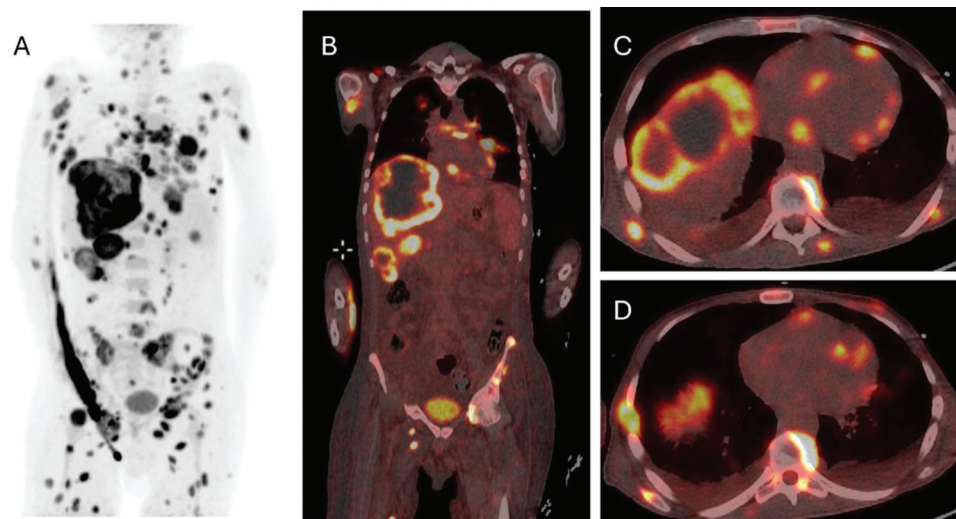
Patient 1 Whole-body PET maximum intensity projection (MIP) image (A) and fused PET/CT coronal (B) and axial (C, D) images demonstrate extensive FDG-avid metastases involving the liver, lungs, musculoskeletal system, adrenal glands, and peritoneum, along with multiple myocardial metastases.
